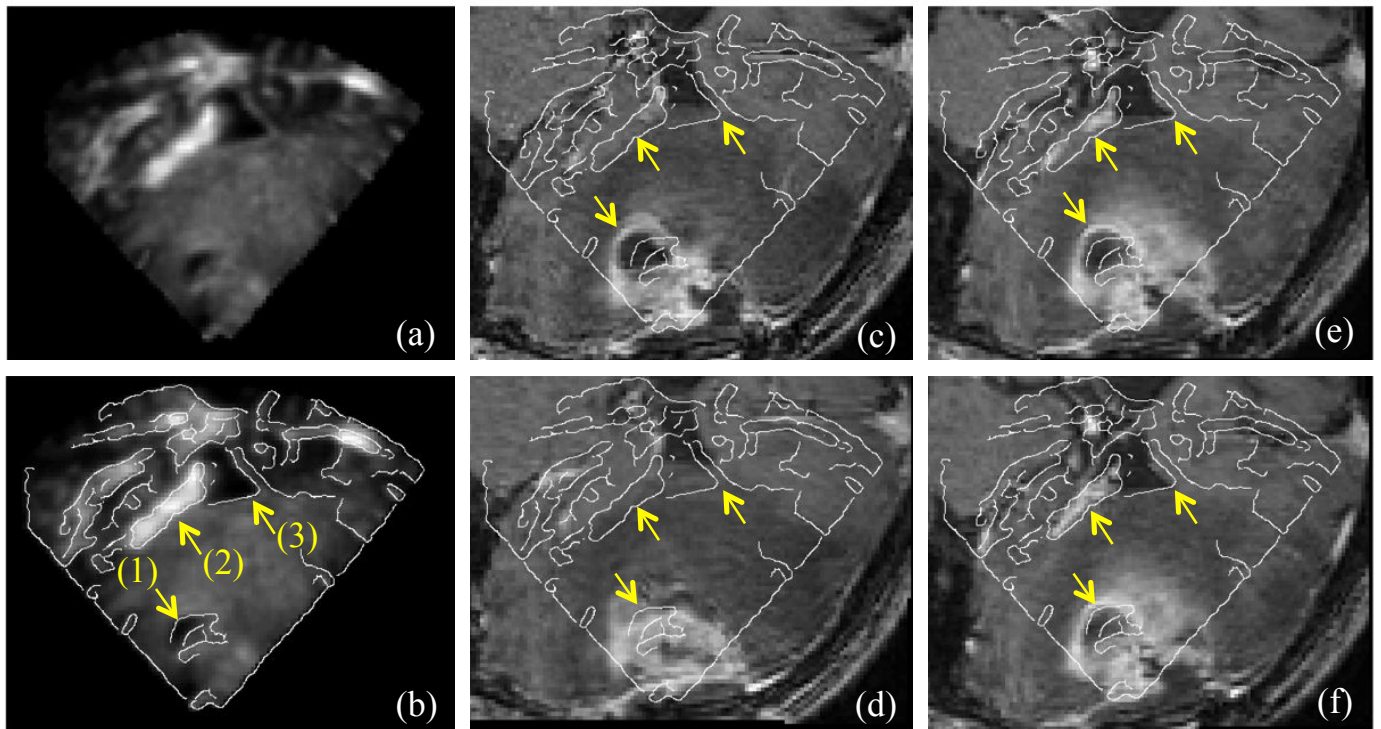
Corresponding intra-operative US and pre-operative MR images. The structures (1) to (3) are respectively the tumor boundary, choroid plexus and the lateral ventricle. (a) and (b) are the same US image, without and with contours overlaid. (c) to (f) are the corresponding MR images, with the contour overlaid to aid comparison. (c) initial alignment. (d) to (f): nonrigid registrations with respectively NMI, α -MI and SeSaMI. Note that all registrations are done in 3D.
